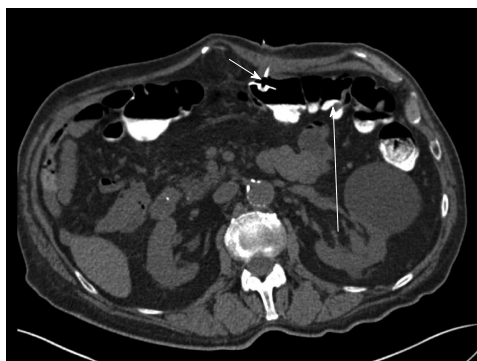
Computed tomography of the abdomen confirmed a buried bumper syndrome with displacement of the internal bumper (short arrow) into the transverse colon (long arrow).
